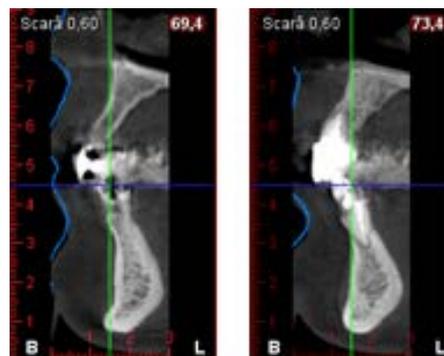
A CBCT scan emphasizes internal root resorption perforation
